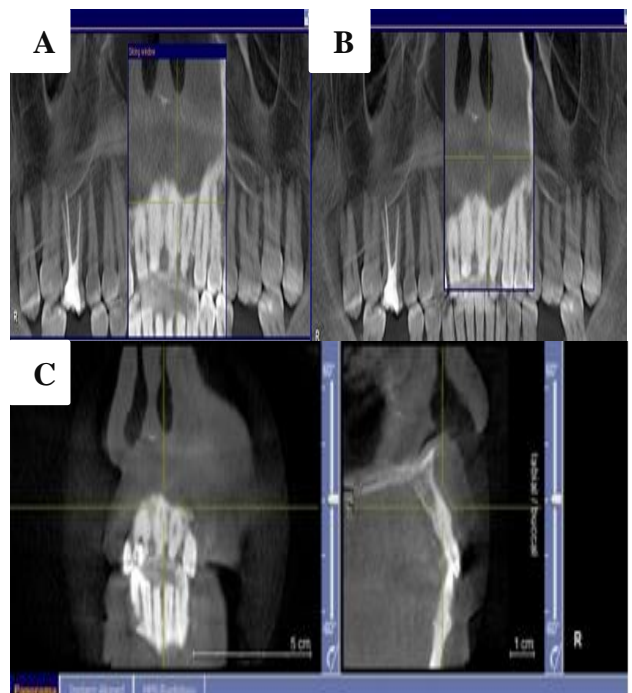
(A, B and C) Cone beam computed tomography CB-CT radiograph.
